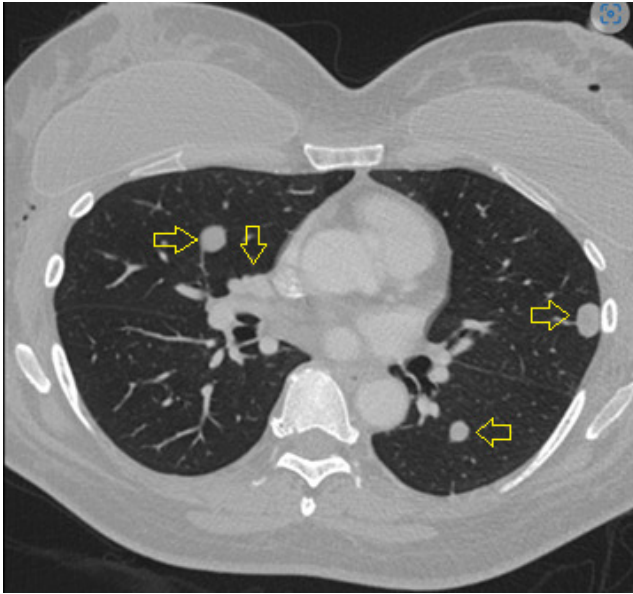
CT slide 158/376 Multiple pulmonary and pleural based nodules
